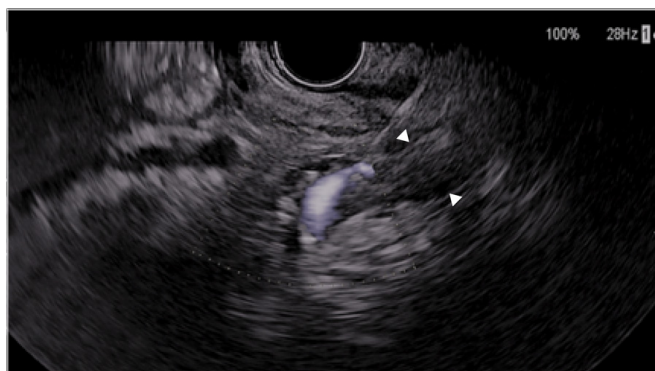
Injection of thrombin into a vessel showing colour Doppler flow (no coil in vessel) with immediate formation of echogenic thrombus in the vessel lumen (arrowheads).
